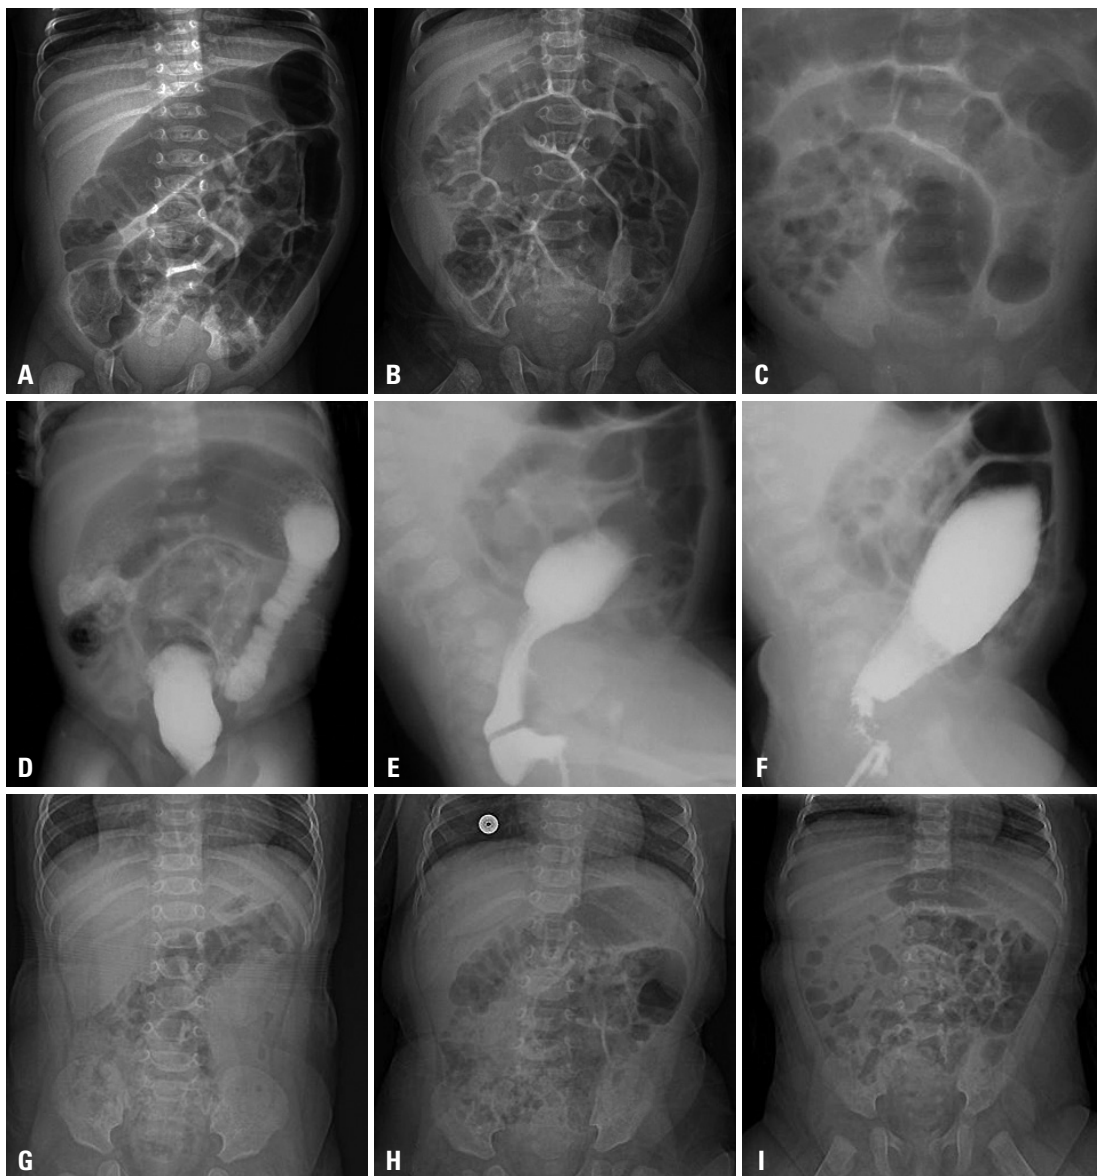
Plain radiograph findings similar to Hirschsprung's disease appeared (A, B and C). Barium studies (D, E and F) showed transition zones. After conservative treatment, symptoms disappeared, and the radiographs normalized (G, H and I). Figures (A, D, F), (B, E, H) and (C, F, I) are taken from the same patients, respectively.
